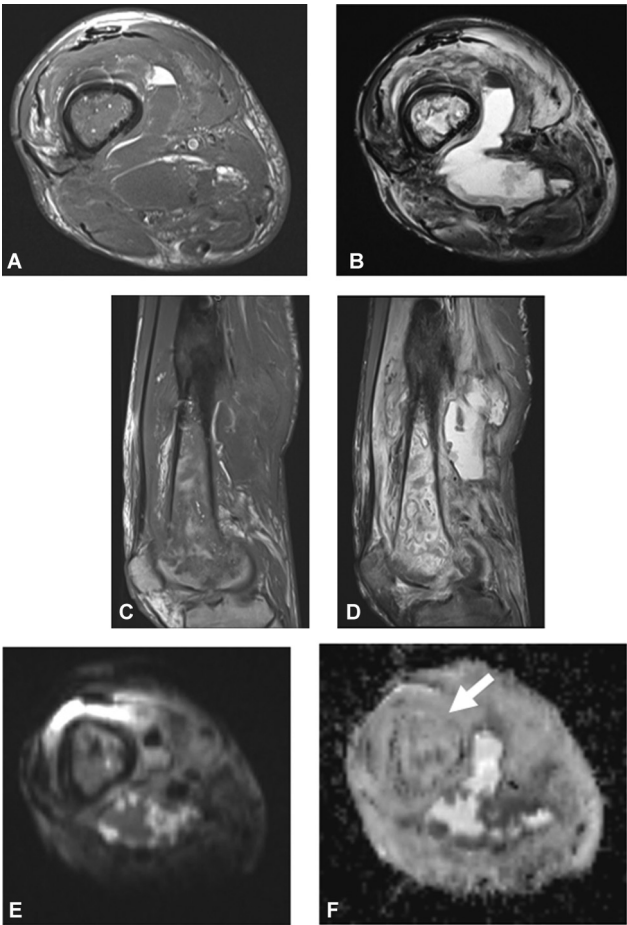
Patient with soft-tissue abscess and osteomyelitis of the femur. (A) Axial T1-weighted (T1W), (B) axial fat-saturated T2-weighted (fsT2W), (C) sagittal T1W, and (D) sagittal fsT2W images of the femur showing lack of the “ghost sign.” Corresponding (E) diffusion-weighted imaging (DWI) and (F) apparent diffusion coefficient (ADC) map of the region of interest showing the “ghost sign” (arrow).
